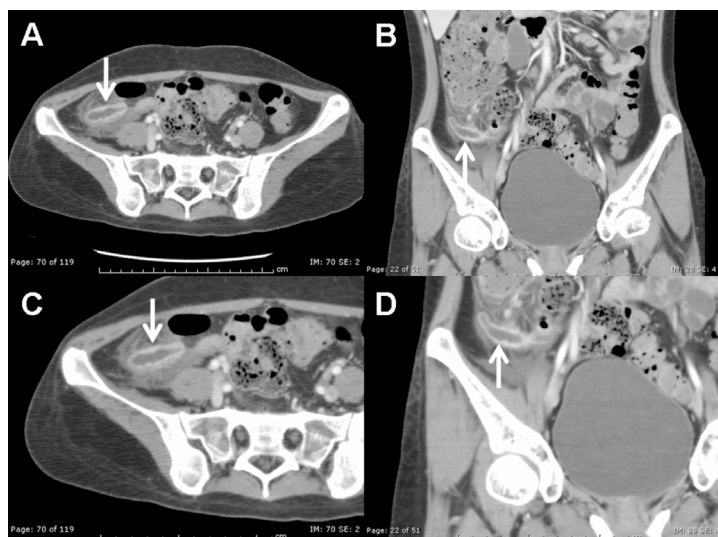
CT abdomen demonstrates a thick and enhanced wall vermiform appendix (arrow) with fluid-filled lumen, measuring 11 mm in diameter. There is associated moderate periappendiceal fat reticulation, fascial thickening and secondary inflammation of the terminal ileum. Minimal free fluid is noted. (A, Non-contrast axial CT; B, non-contrast coronal CT; C, post-contrast axial CT; D, post-contrast coronal CT).
